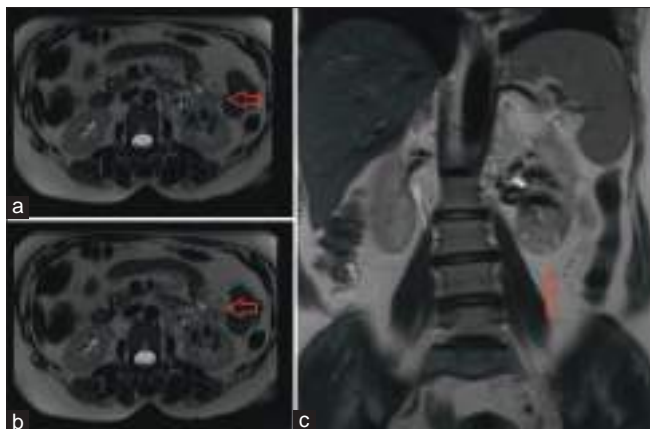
(a-c) MRI views (Red Arrow) showing left renal lower pole mass with central necrosis
